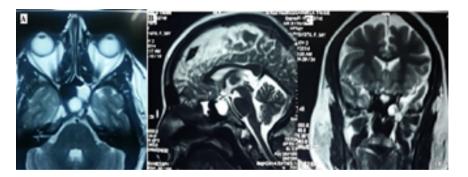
MRI T2 Images. A: Axial view showing defect in the left anterior wall of sphenoid sinus with hyperintense signals of CSF. B: Sagittal view showing CSF collection in sphenoid sinus. C: Coronal view indicating brain parenchyma and CSF on the left side.
